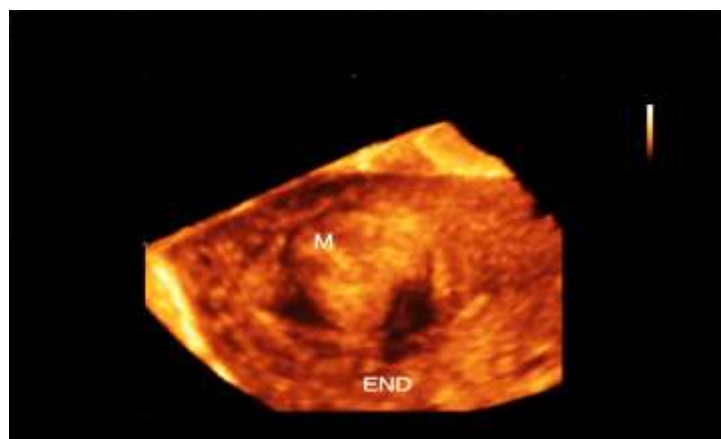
3D ultrasound surface rendering of large submucosal myoma.
